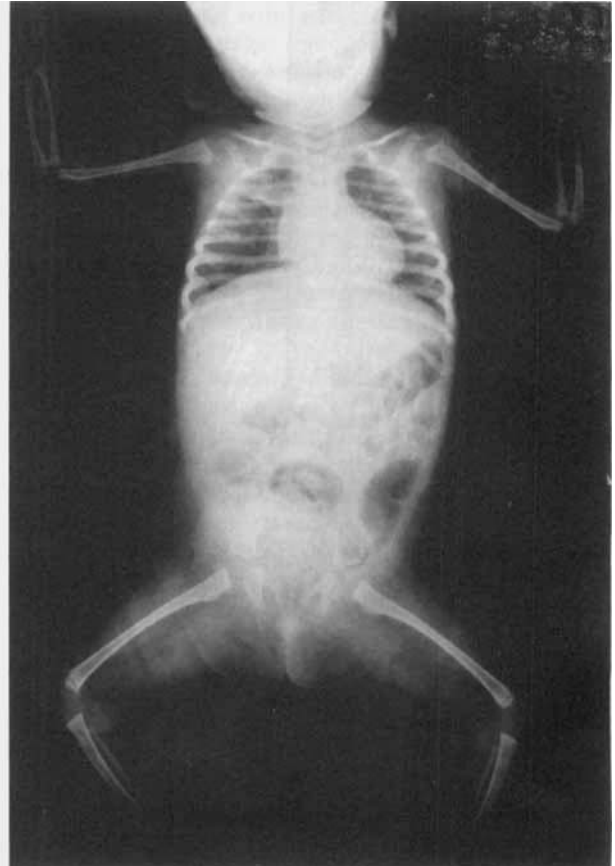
Roentgenographs of the skeleton. Note thin long bones and ribs.
